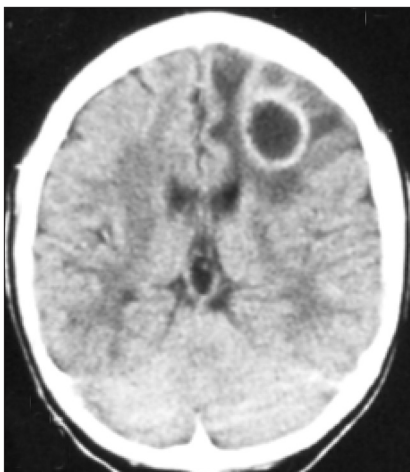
CT scan image of the brain showing solitary ring enhancing lesion in the left frontal lobe in a patient with HIV/AIDS
